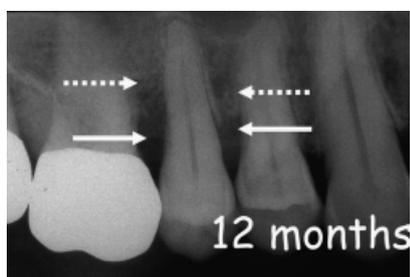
X-ray at 12-month follow-up. Compared with the baseline radiograph, bone fill can be observed.
